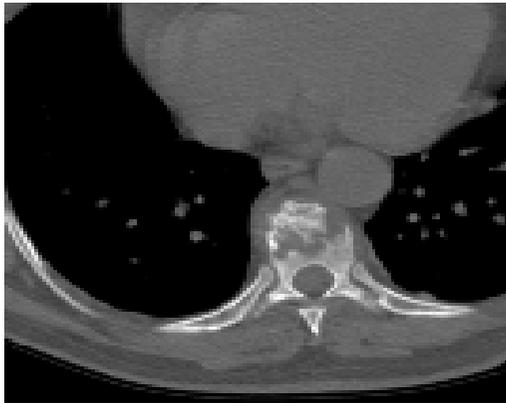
CT demonstrates lytic lesion of vertebral body with cortical destruction and soft tissue invasion.
